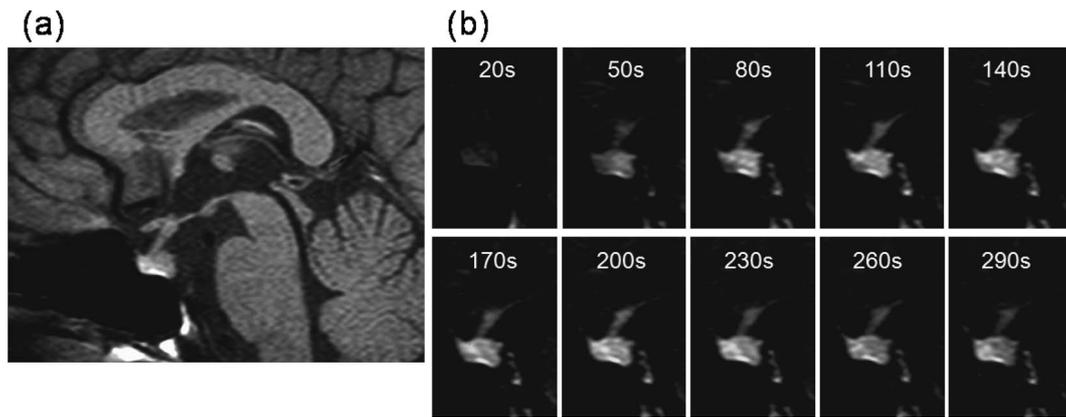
Pituitary MRI. (a) The posterior pituitary was swollen and the thickened stalk was deviated viscerally. (b) Enhancement of the posterior pituitary was also detected. The serial images were obtained at the indicated seconds (s) after Gd-DTPA injection.
